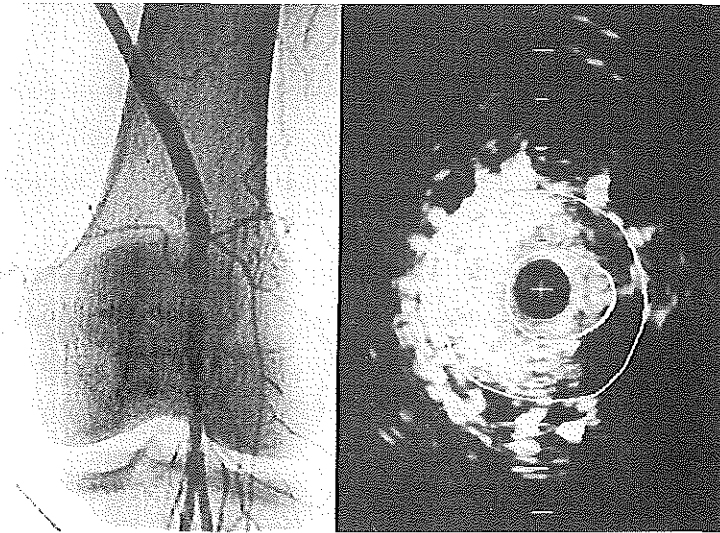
Left panel: angiography. Right panel: Intravascular ultrasound (IVUS) cross-section. Angiography of an endovascular stent-graft showing a stenosis at the distal attachment system. In the IVUS cross-section is seen that the stenosis is caused by intimal hyperplasia.
